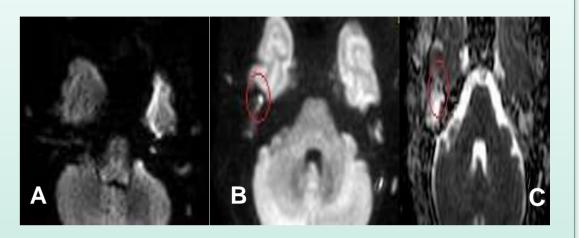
(A) Axial EPI DWI show no high signal in right middle ear (B) Axial Non- EPI DWI showed a small focus of high signal in right middle ear cleft, (C) ADC revealed corresponding low signal.
